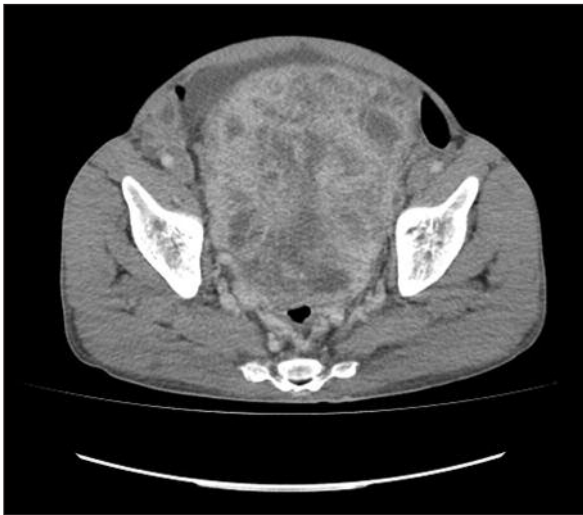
CT scan showing the huge necrotic abdominal mass.
